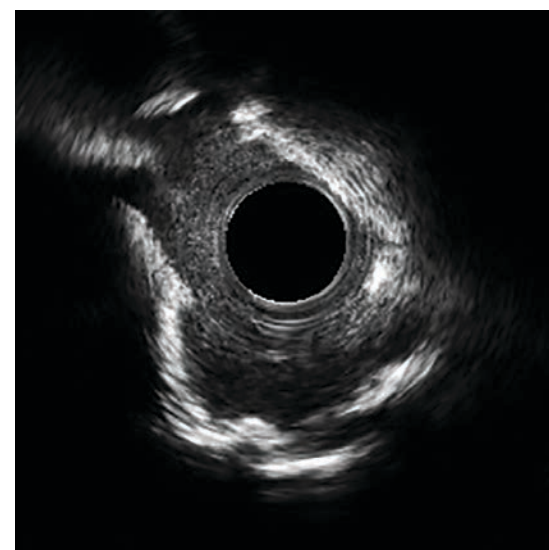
Intravascular ultrasound of distal left main coronary artery.
